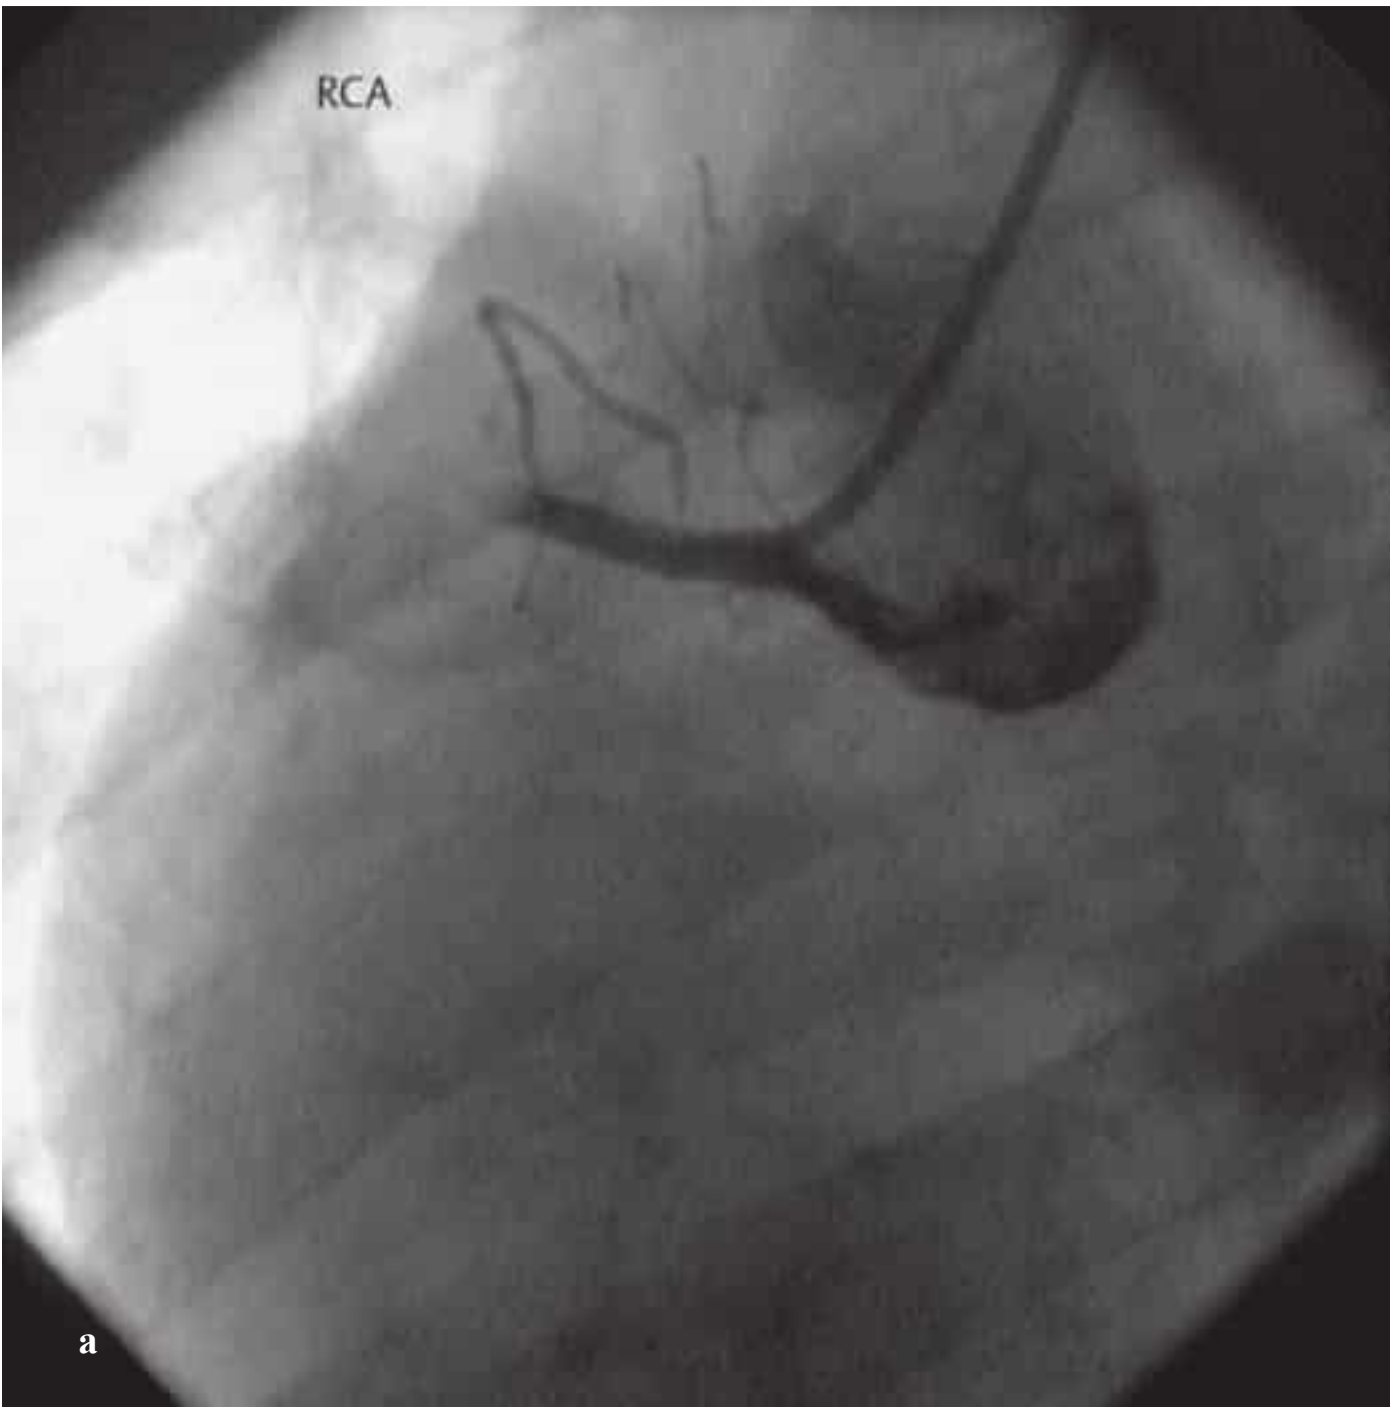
a–f Acute occlusion of the RCA with reperfusion following acute stent PTCA. MR images were acquired 6 months after the intervention.
